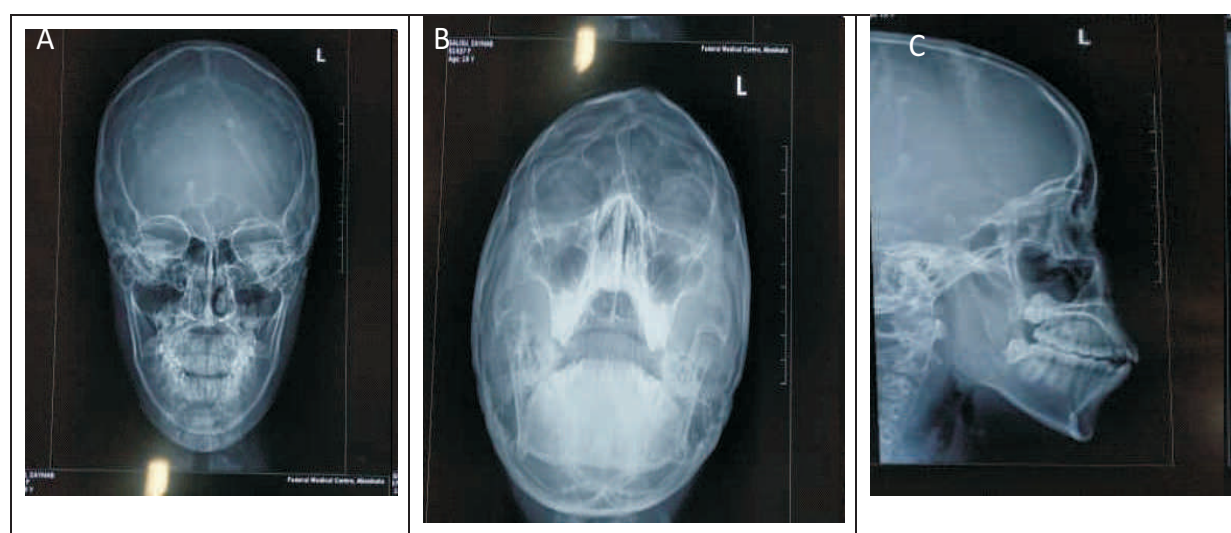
X-Ray Paranasal Sinuses – A, occipito-frontal view showing normal aeration of the frontal sinuses; B, occipito-mental view showing mucosal thickening of the maxillary sinuses and well pneumatized sphenoid sinuses; C, lateral view showing normal aeration of the frontal sinuses.
